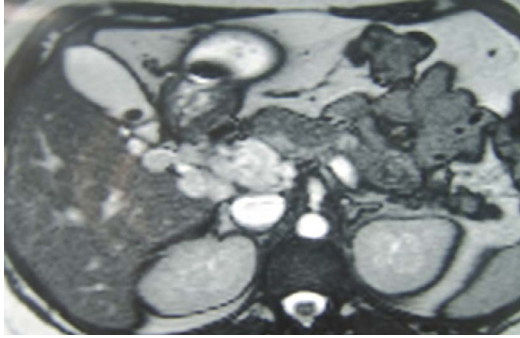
MRI Picture Axial Cut.
